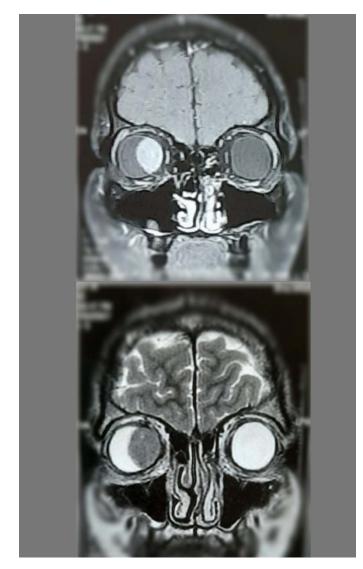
MRI Brain with Orbit (P+C) - right sided intraocular mass lesion size 2.2x1.7x2.1 cm at nasal side involving choroid, appearing; Fig-2a. Iso to mild hyper intense on T1W image; Fig. 2b. hypointense on T2W image
